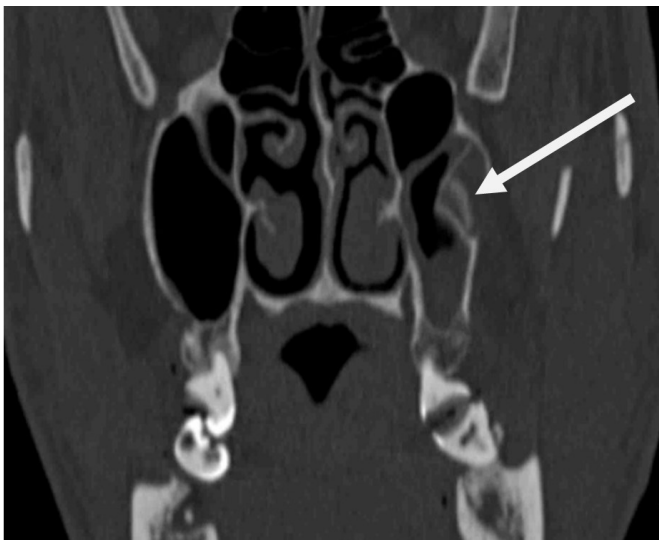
CT traumatic fracture of the posterior wall of the maxillary sinus (marked with an arrow)
